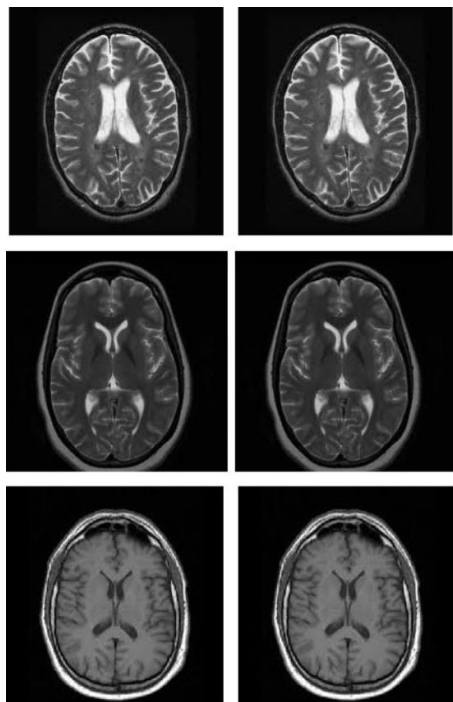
MRI, T2, transversal
